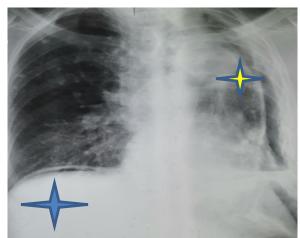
Chest X-ray showing pneumoperitoneum (blue star) and a destroyed left lung field (yellow star)
